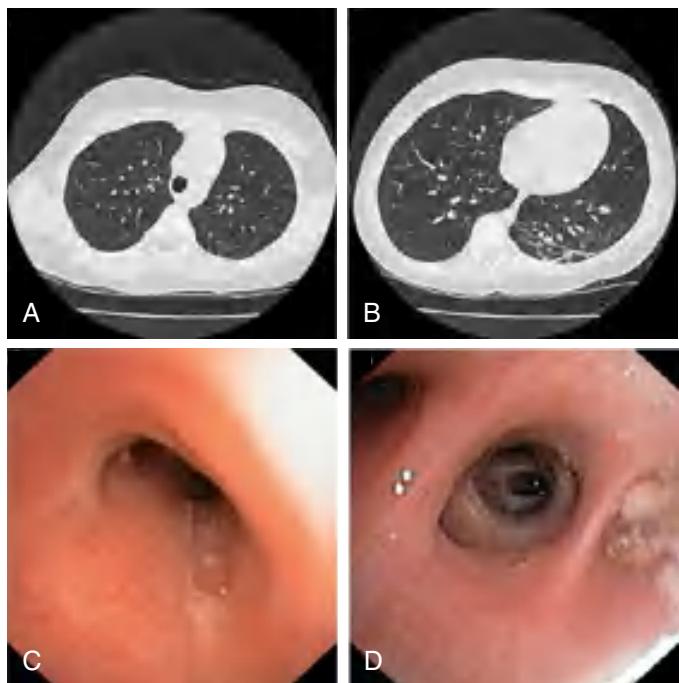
High-resolution chest CT scans (A and B) and bronchoscopy images (C and D) in a child with bronchiectasis. (C and D) Bronchoscopy findings. Images from a chest high-resolution computed tomography (cHRCT) scan (A and B) in a 10-yr-old girl who presented with a chronic wet cough. The child was treated with a 2-wk course of IV antibiotics (after failing oral antibiotic treatment). The scan was reported as having no evidence of bronchiectasis by pediatric radiologists. At bronchoscopy thick mucus was seen in the trachea (C) and the right lower lobe (D). The case highlights the need to consider the diagnosis of bronchiectasis on the basis of history, examination findings, and using the pediatric cutoff (bronchoarterial ratio >0.8) for defining bronchiectasis on the cHRCT scan. (From Goyal V, Grimwood K, Marchant J, et al. Pediatric bronchiectasis: no longer an orphan disease. *Pediatr Pulmonol*. 2016;51:450–469.)
